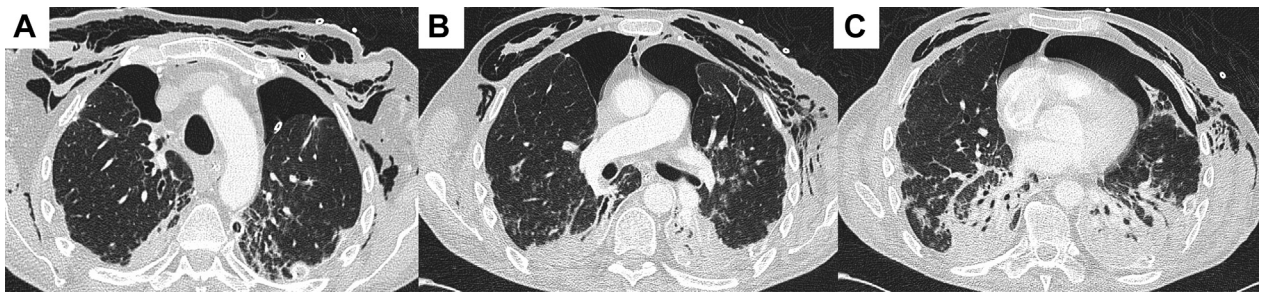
A-C, Axial slices from a chest CT scan demonstrating progression of bilateral lower lobe consolidation and bilateral pneumothoraces with extensive subcutaneous emphysema throughout the superficial soft tissues of the chest extending into the mediastinum.
